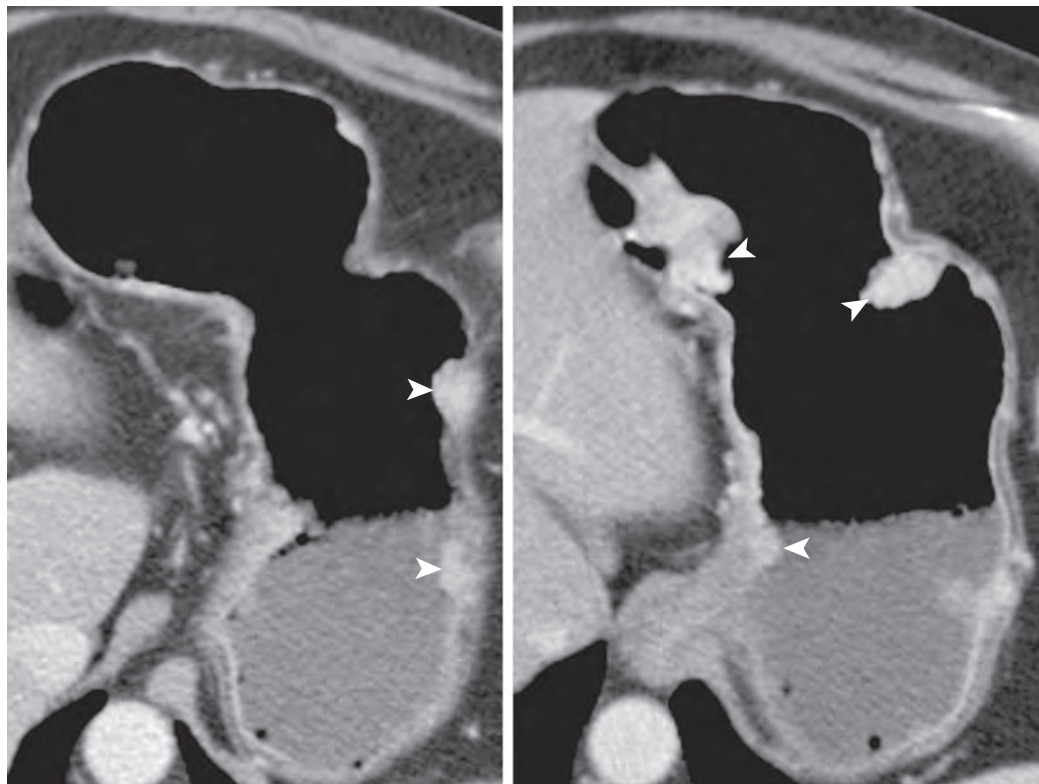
Gastric carcinoid tumors on CT. Sequential CT scans show multiple carcinoid tumors as enhancing polypoid masses (arrowheads) in the proximal stomach.
